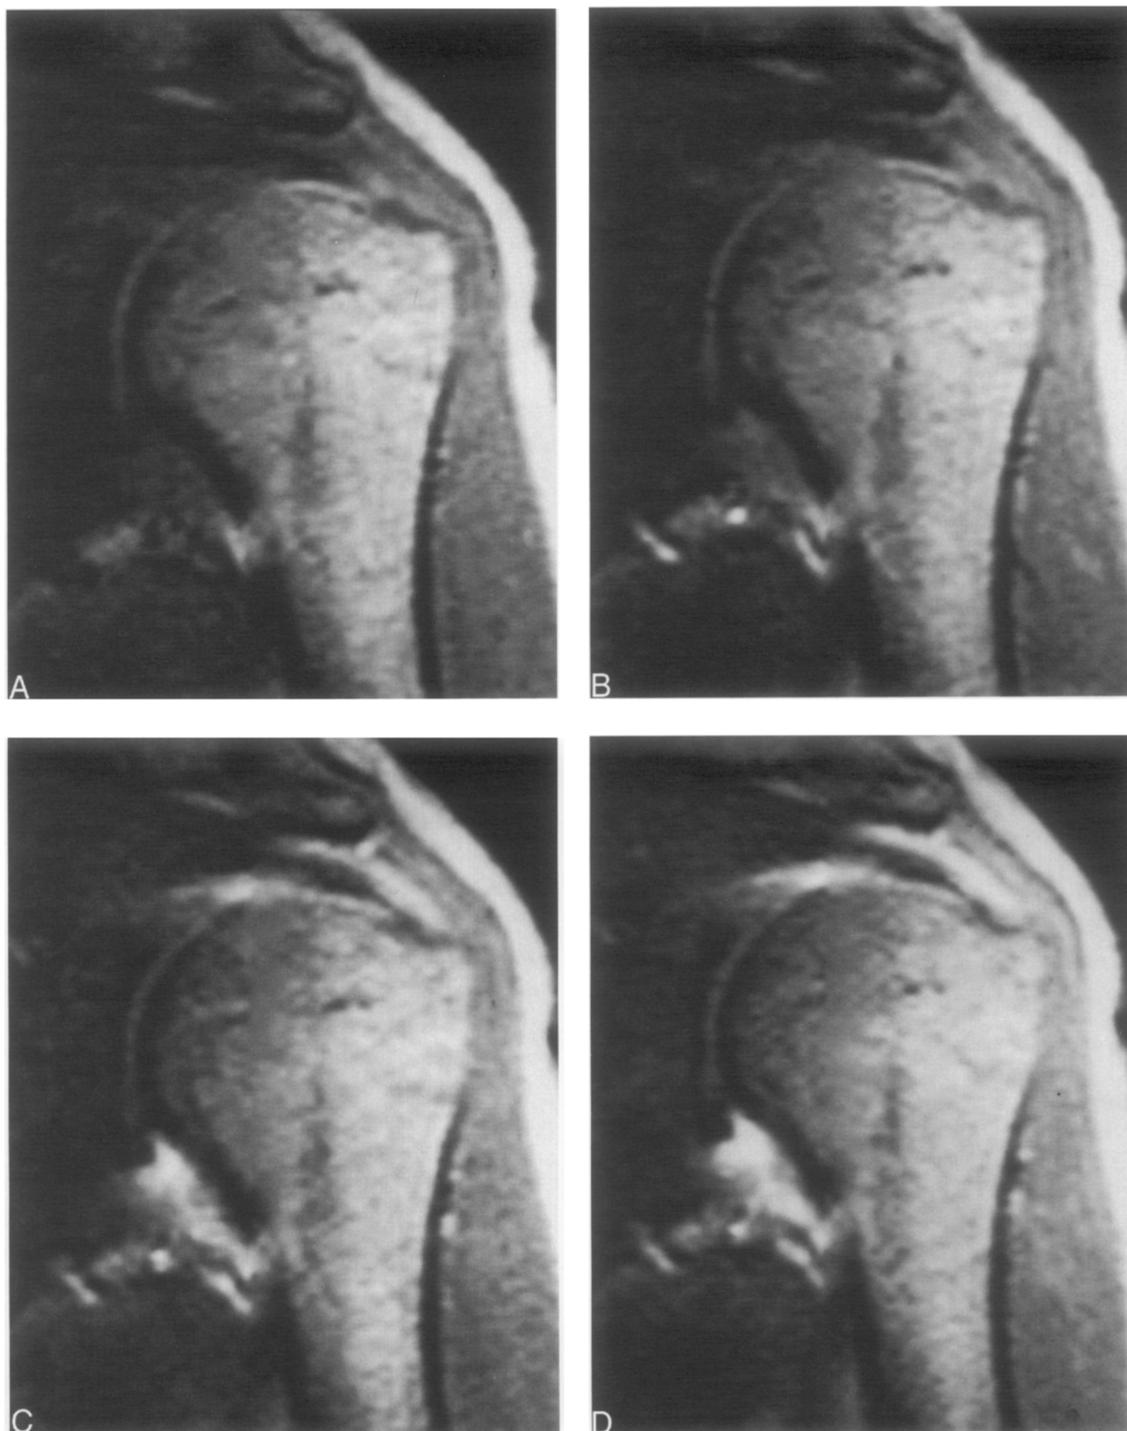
Dynamic magnetic resonance imaging enhanced with Gd-DTPA. Dynamic gradient-recalled echo images obtained before (A), 33 (B), 66 (C), and 110 (D) seconds after Gd-DTPA administration. Dramatic increase in signal intensity in glenohumeral joint and subacromial bursa is noted.
